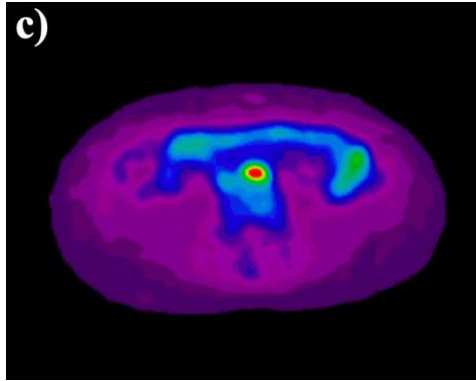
a) Transaxial image of CT Atlas. b) CT image of abdominal aorta. c) the corresponding PET image.
